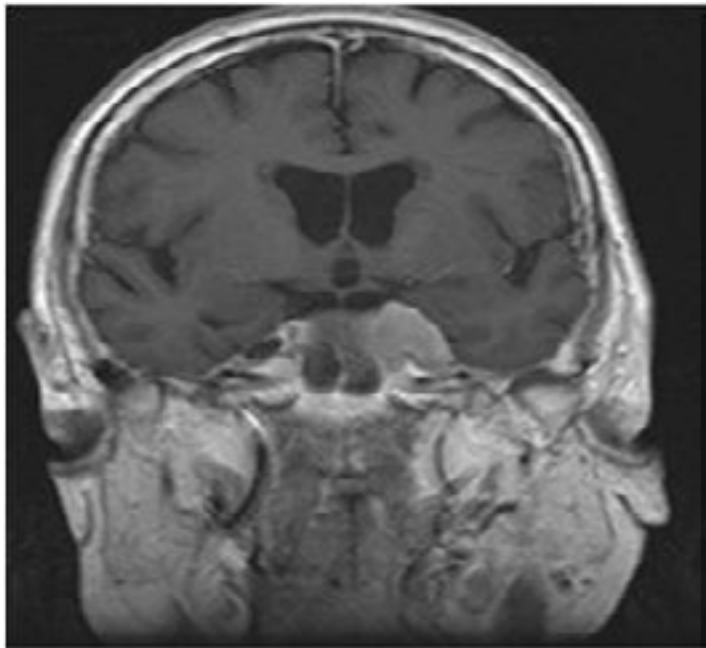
Coronal T1 weighted magnetic resonance image with gadolinium showing that the mass encasing the left carotid artery.
